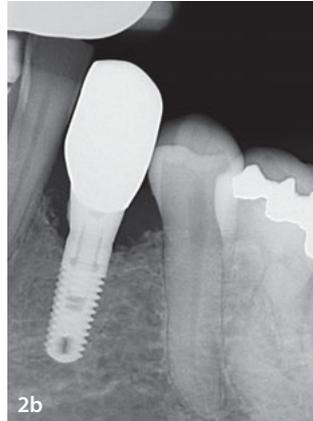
A periapical radiograph of the implant revealed a potential excessive cement mass on its mesial aspect.
